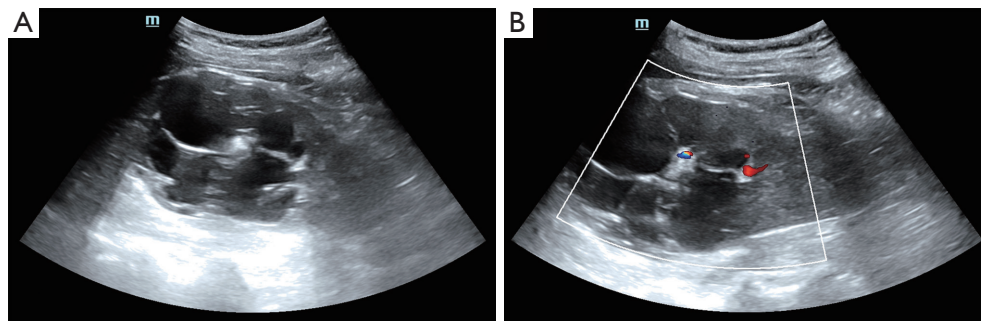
Ultrasound showed a complex cystic lesion with many septa. (A) The septa were thick and uneven. Some septa had calcification; (B) Color Doppler flow imaging displayed dot-linear blood flow signals in some septa.
